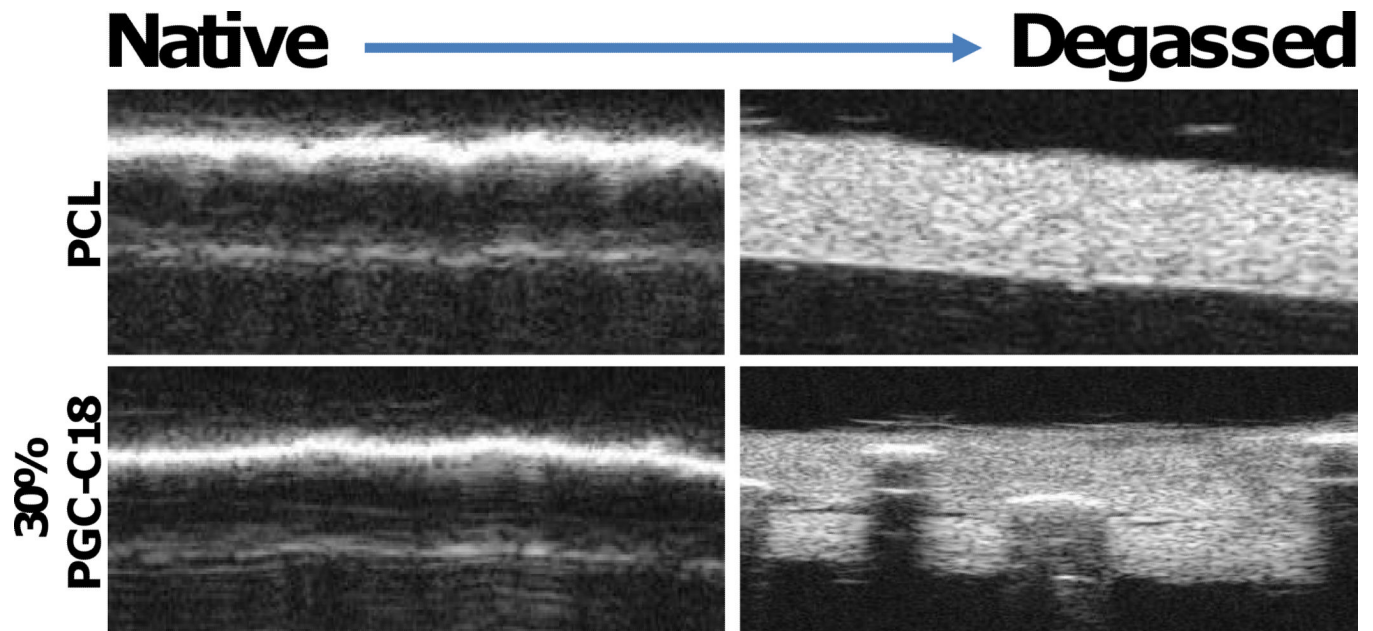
Cross section of films in B-mode, showing presence of an air layer within the native materials (left), and removal of the air layer with ultrasound treatment (right). When the air layer is present, the B-mode ultrasound pulses are completely reflected off the surface and the meshes are not visible in the images. When the air layer is removed (right), B-mode ultrasound pulses pass through the surface and the meshes become visible in the images.
